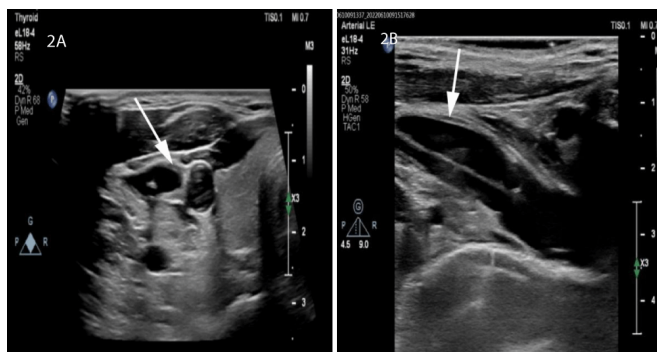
Ultrasound after observation (A: Sagittal plane, B: coronal plane): right internal jugular vein proximal wall slightly thickened (lesion site indicated by arrow)
